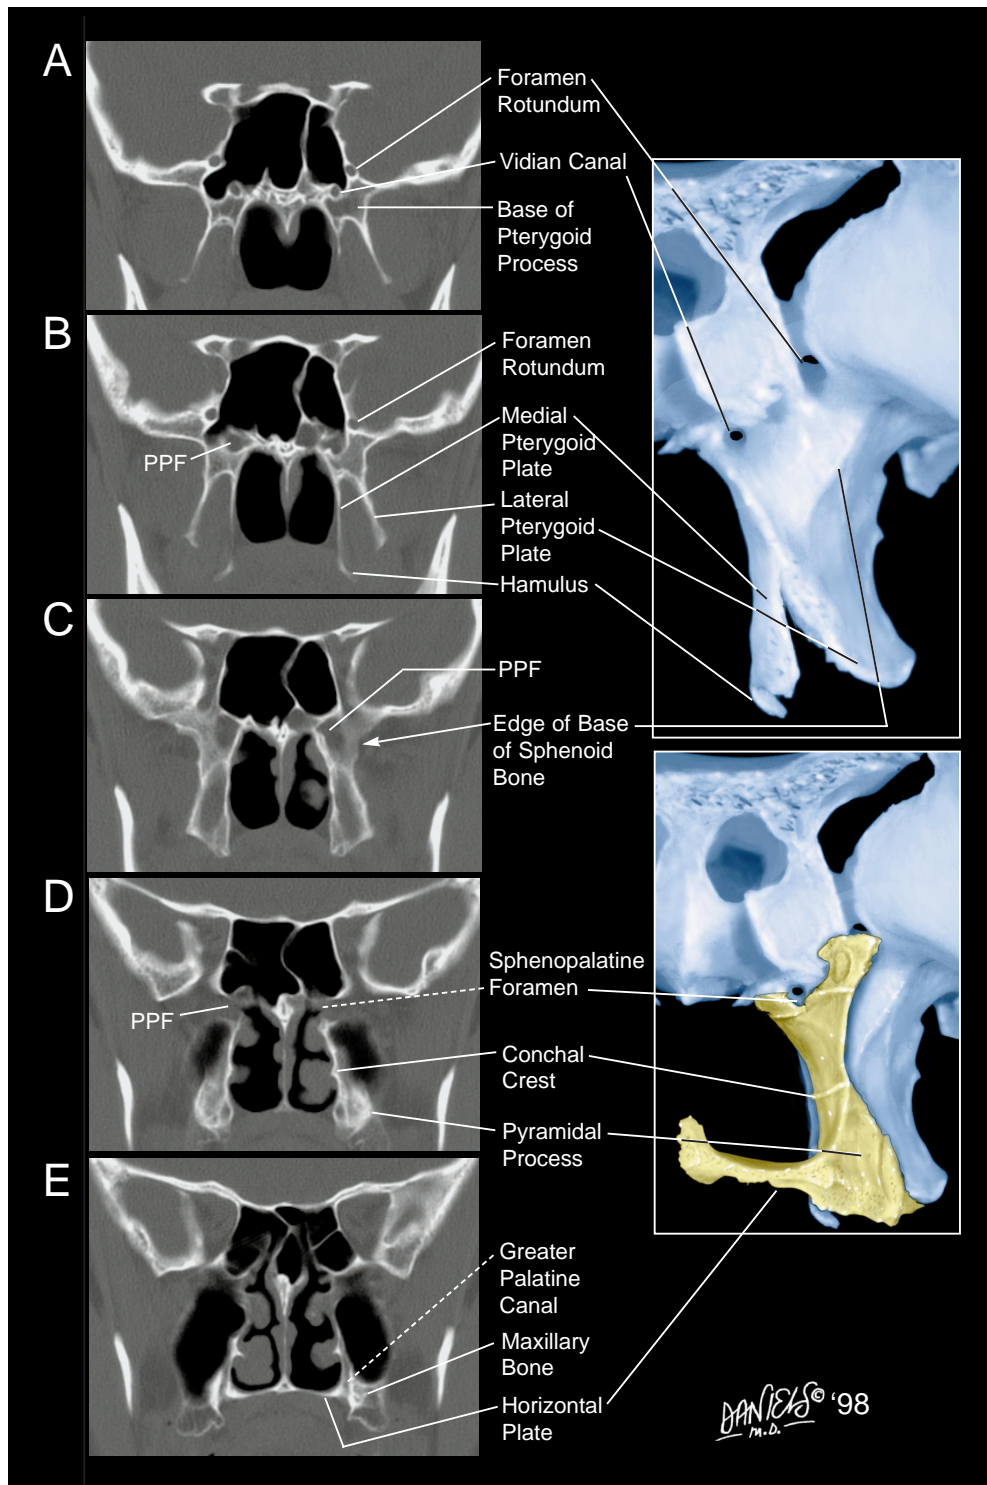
Coronal CT scans show osseous anatomy of the structures marginating the PPF posteriorly to anteriorly and referenced to inserts in Figure 4.
